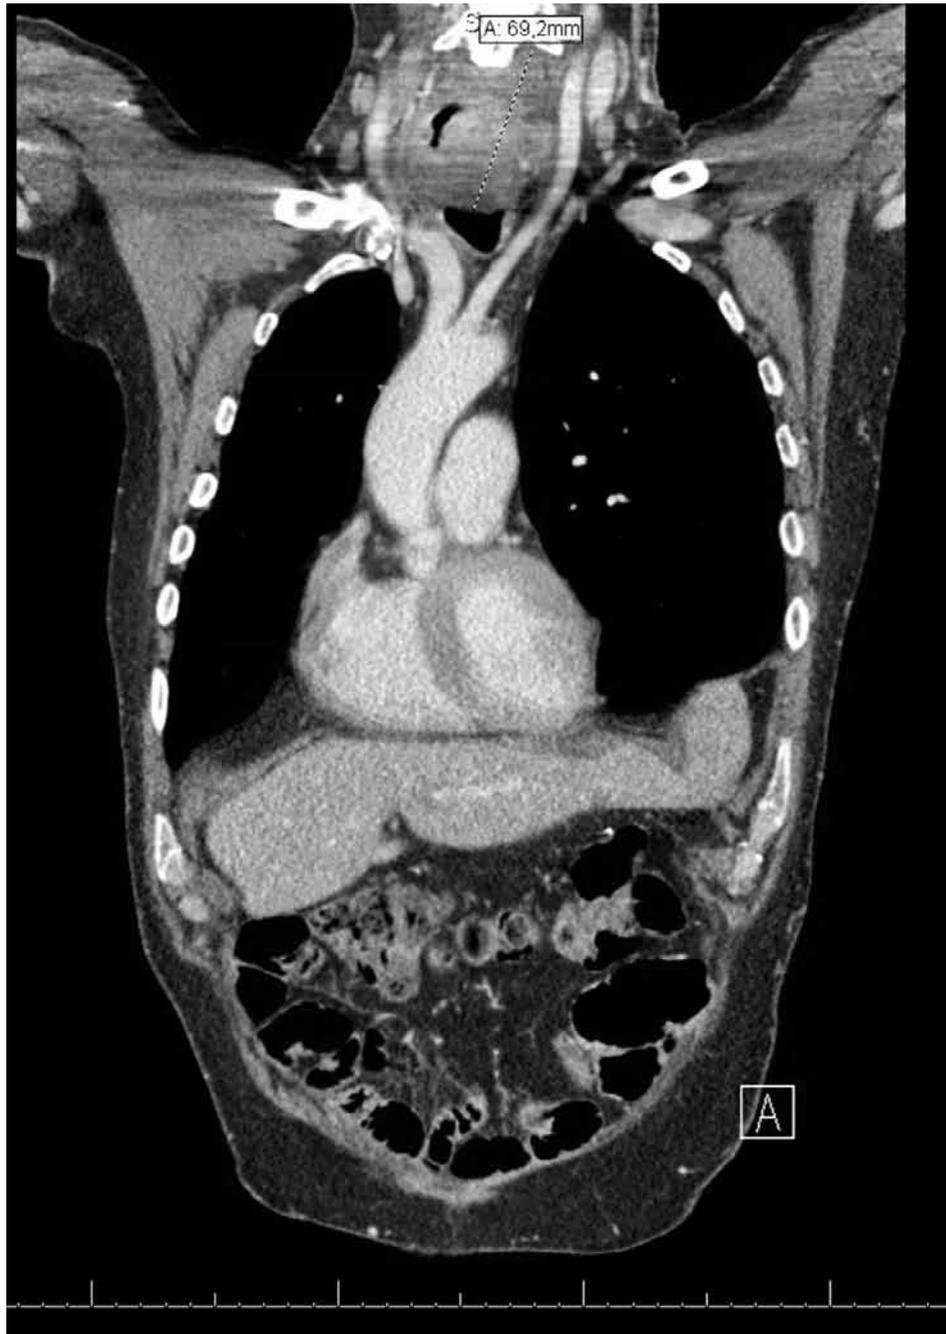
Chest computed tomography scan (CT scan) (case 1, tumor 2) demonstrating a tumor mass in the cervical native esophagus with suspected tumor invasion in the left thyroid gland.
